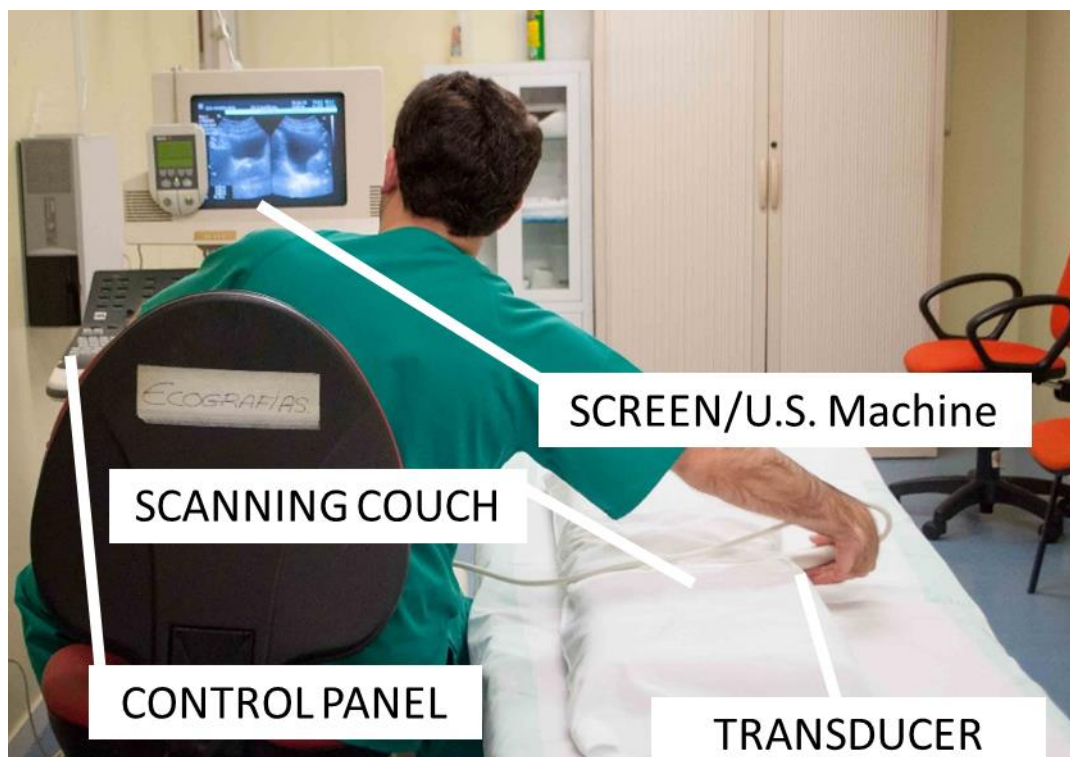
Sonographer overstretching to reach the target.
